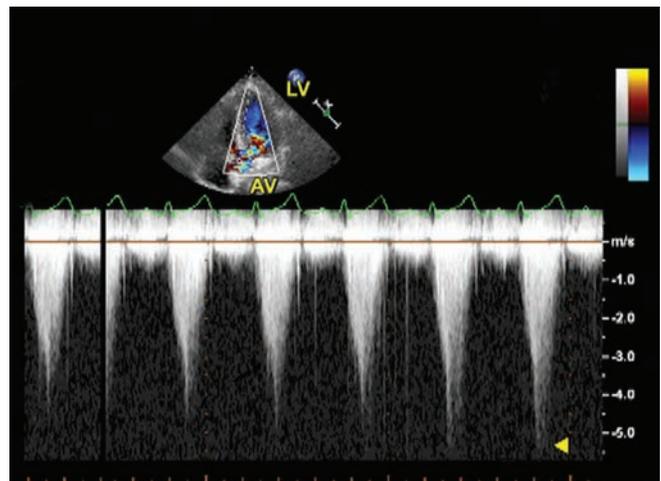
LVOT interrogation by CW Doppler demonstrates a very high gradient of 123 mm Hg.
